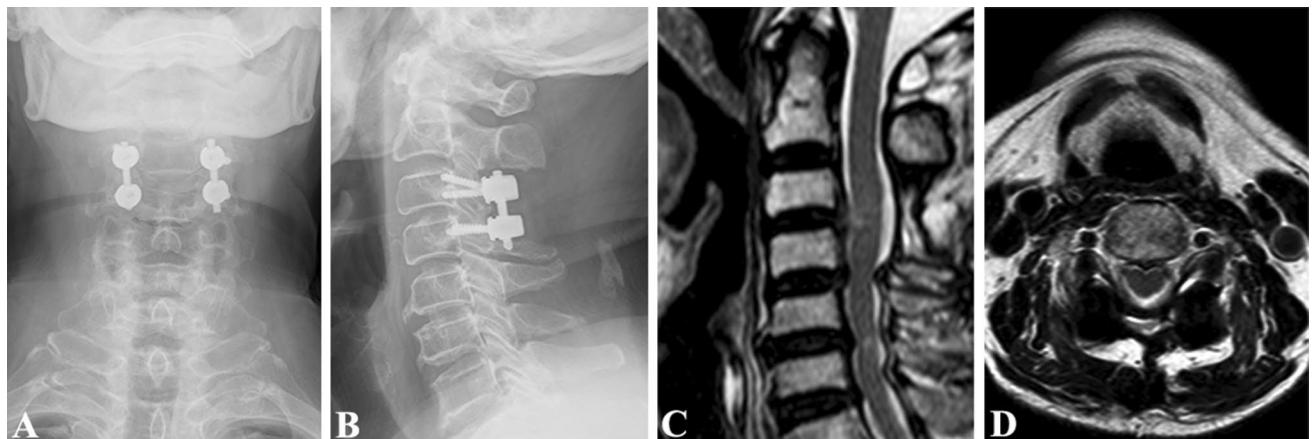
Six-month follow-up X-ray (a, b) and T2-weighted MR images (c, d) demonstrated C3/4 spinal canal was enlarged and there was no neurological compression there
